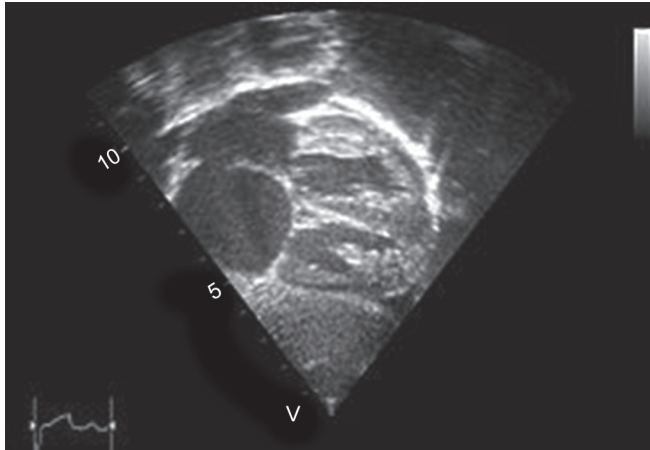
Echocardiogram in atrial septal defects, secundum type. Atria are toward the left and the apex toward the right. Secundum defect is seen as a discontinuation of interatrial septum. Dilated right atrium is noted inferiorly. Enlarged pulmonary veins are seen entering left atrium above
